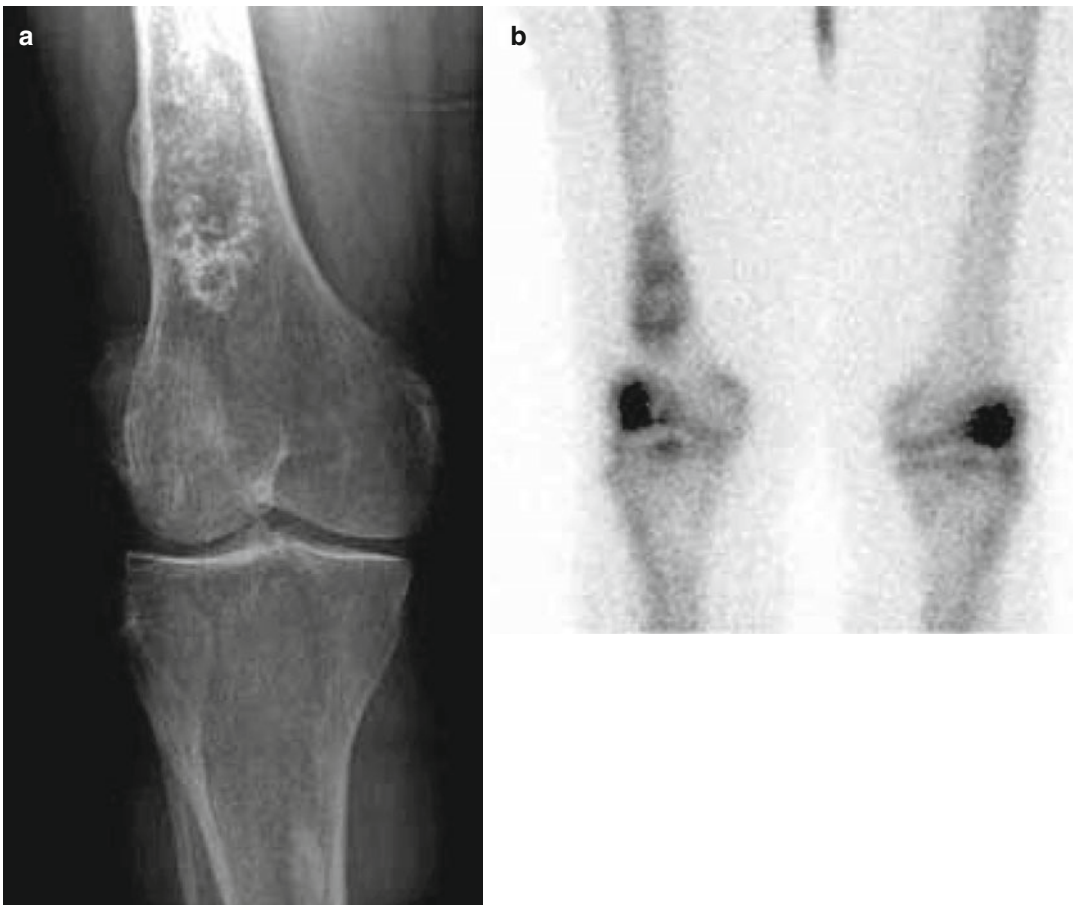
Patient with an enchondroma in the right distal femur, (a) X-ray graphy, (b) bone scintigraphy
